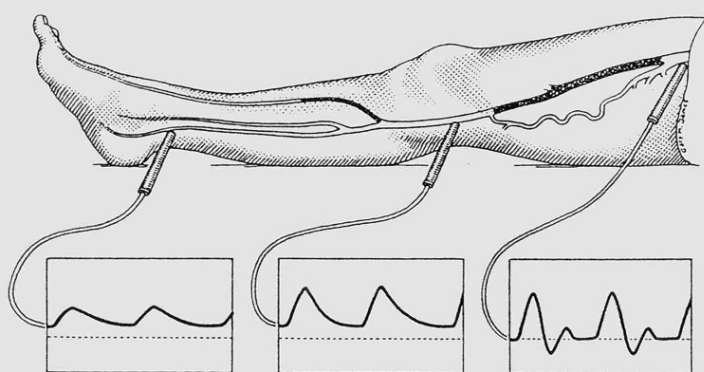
Progressive damping of the Doppler waveform down the arterial tree.
